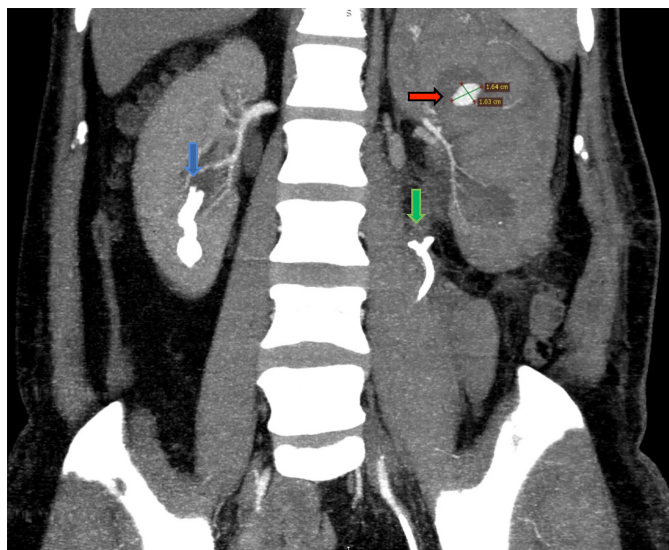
CT angiogram maximum intensity projection (MIP), coronal view demonstrating an arteriased sac at the location of interlobar arteries of the upper pole (red arrow). The green vertical arrow shows a displaced DJ stent. The blue vertical arrow shows a large radiodense calculus in the lower calyx of the right kidney.
